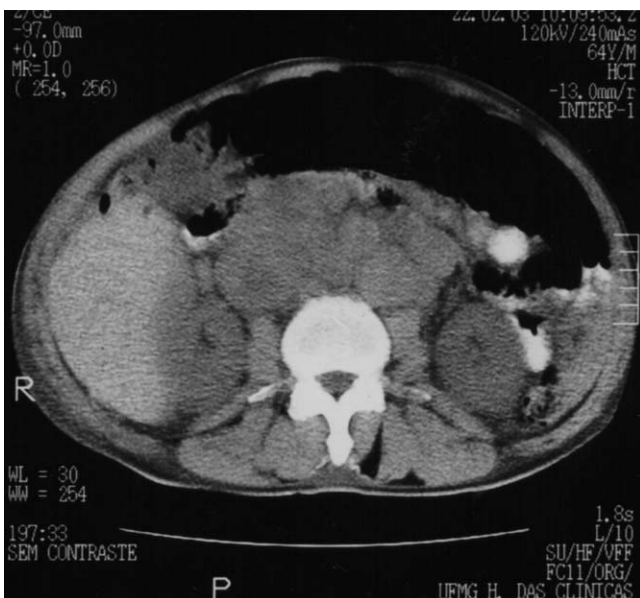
CT of the abdomen showing extensive retroperitoneal lymphadenopathy.
